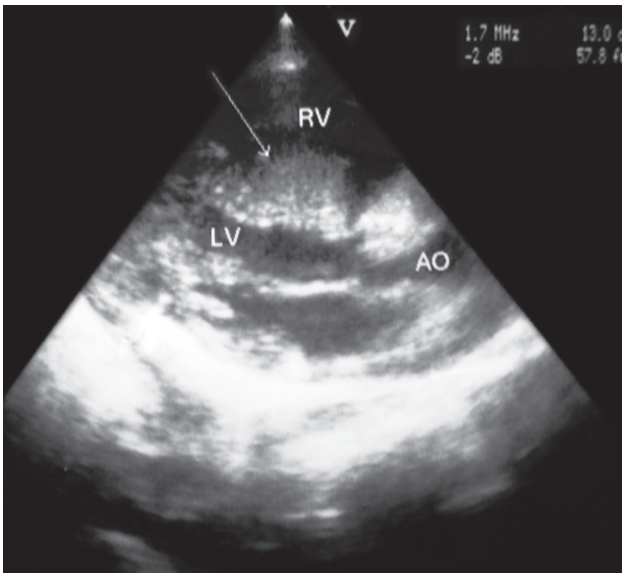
A preoperative echocardiographic view showing a 31×27 mm echodense in the right ventricle originating from the interventricular septum and protruding through the right ventricular outflow tract.
